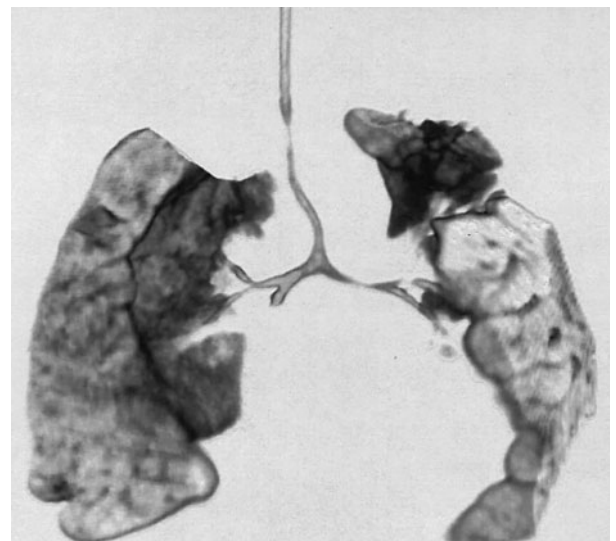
CT scan with three-dimensional reconstruction to demonstrate anatomy of the trachea in a patient with congenital tracheal stenosis involving the majority of the tracheal length.
